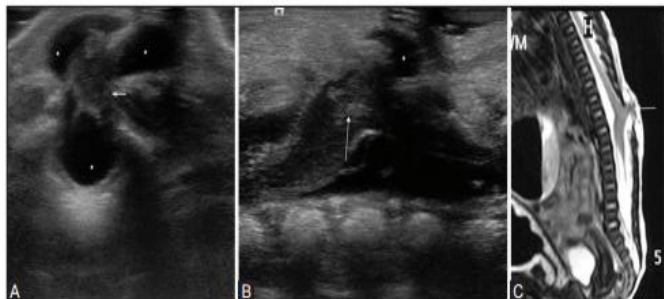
(A and B): Lumbar myelomeningocele. Axial (A) Sagittal (B, C) US images reveal herniation of the conus (arrow) with an expansion of ventral CSF space (asterisk). Sagittal T2-weighted MR image reveals the defect in posterior elements of upper lumbar vertebrae with herniation of neural tissue and CSF spaces (arrow)
